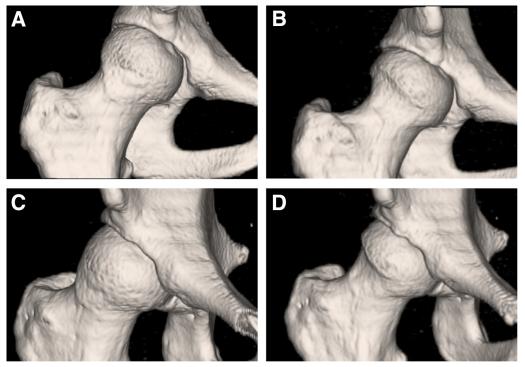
Preoperative and postoperative 3D CT scan of a cam-type femoroacetabular impingement. (A) A preoperative low-dose 3D CT scan of the right hip in a 21-year-old female demonstrates a cam-type deformity on the anterior are of the femoral head junction. (B) The postoperative 3D CT scan demonstrates the resection of the cam-type deformity. (C) Preoperative false profile view. (D) Postoperative false profile view. (3D, 3-dimensional; CT, computed tomography.)
